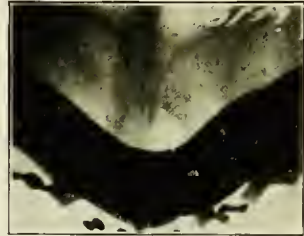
and 2 are radiographs taken on the platform during the reading of the above paper. As no volunteers among the members of the association presented, the janitor of the hall kindly consented
